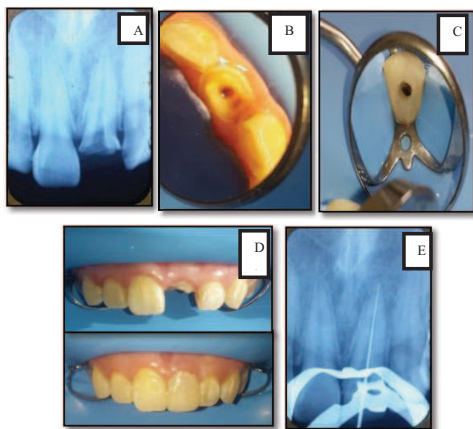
(A) Radiographic retreatment (B) Occlusal view of retreatment (C) Rewalling (D) Access opening (E) Initial Apical File
